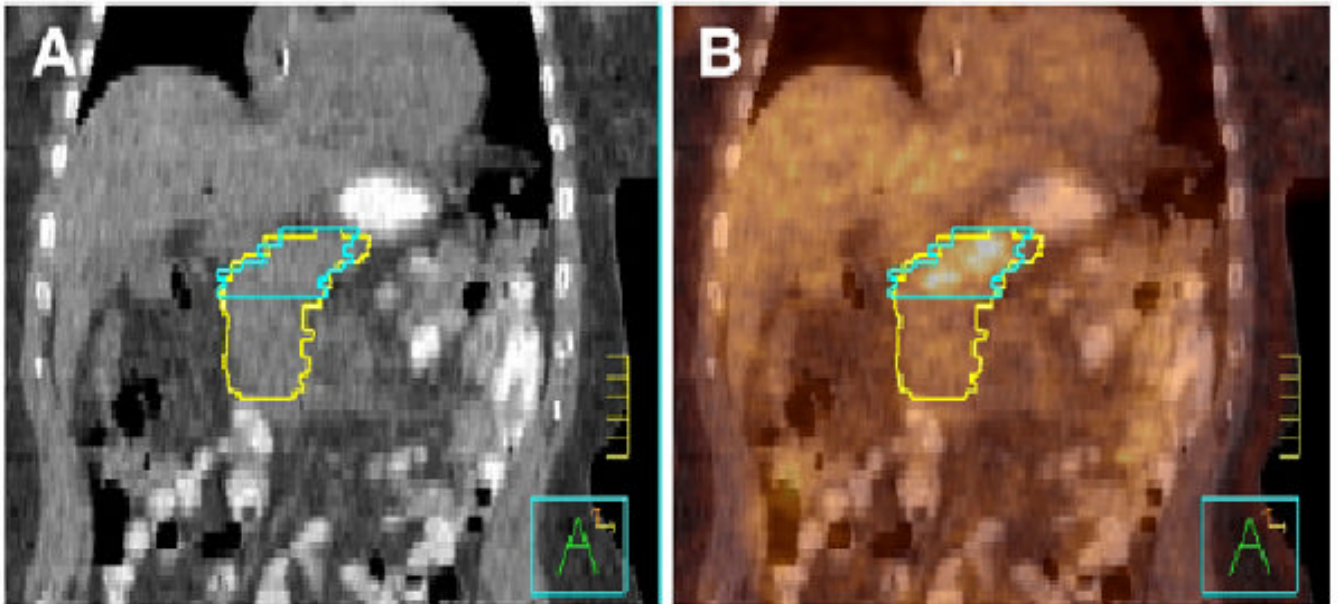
Pancreatic adenocarcinoma delineated on CT alone by radiation oncologist (yellow) and on ^{18}F -FDG PET/CT by nuclear medicine physician (blue). Images are from coronal cut of patient with CT (A) and ^{18}F -FDG PET/CT image fusion (B). Tick marks are 1 cm.
